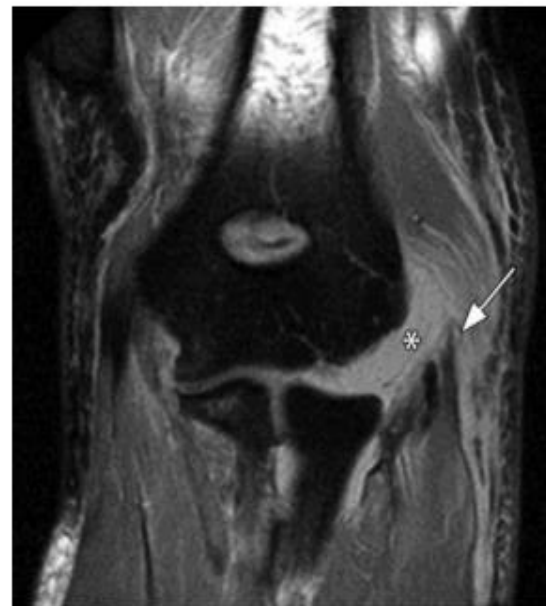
Traumatic injury to the lateral elbow. Proton density-weighted fat-saturated MR image obtained in a 57-year-old man demonstrates avulsion of the common extensor tendon, RCL, and LUCL (arrow), with high signal intensity indicative of fluid in the gap between these structures and the lateral epicondyle (*).
